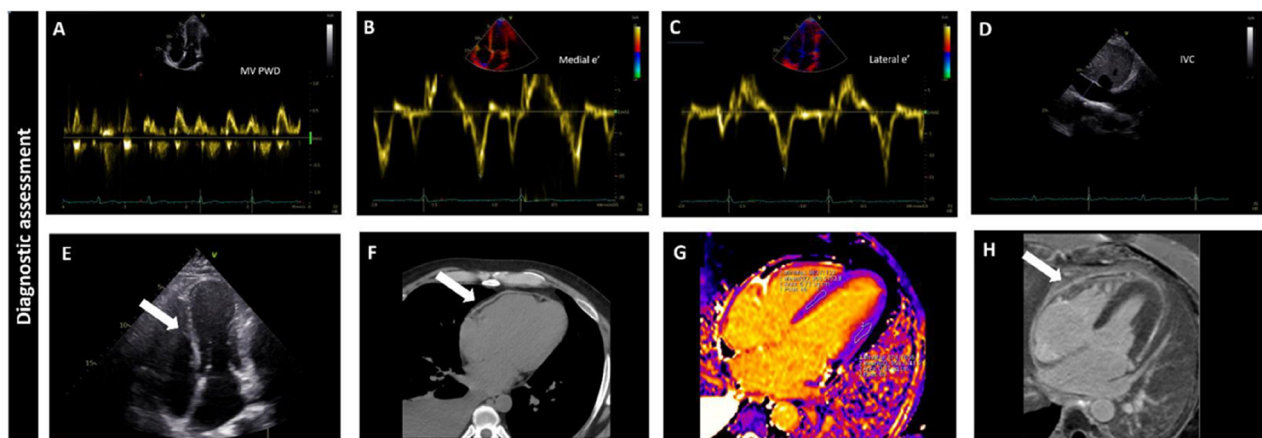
The echocardiogram showed apparently normal left ventricular (LV) systolic and diastolic function (Panel A) with mitral medial e' velocity (Panel B) higher than the lateral one (Panel C), the so called annulus reversus. IVC was markedly dilated without any variation with inspiration (Panel D). During inspiration the interventricular septum showed a left-sided shift (white arrow on Panel E). A thoracic computed tomography was performed and showed increased pericardial thickness without calcifications (white arrow on Panel F); and a cardiac magnetic resonance showed normal myocardial T1 mapping (Panel G) and diffused pericardial late gadolinium enhancement (white arrow on Panel H) (From reference [26]).
